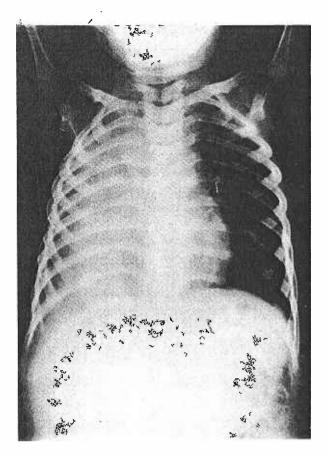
Radiograph of the chest to show extensive pleural effusion.
